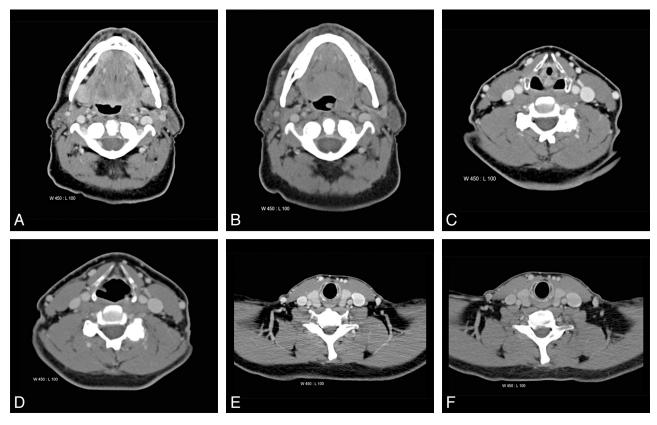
37-year-old male patient with follow-up neck CT for lymphoma at 70 kVp (A, C, E) and corresponding previous CT at 120 kV (B, D, F) at 3 anatomical levels. Note the diagnostic image guality with a higher contrast-to-noise ratio of cervical soft tissues at 70 kVp at all levels.
